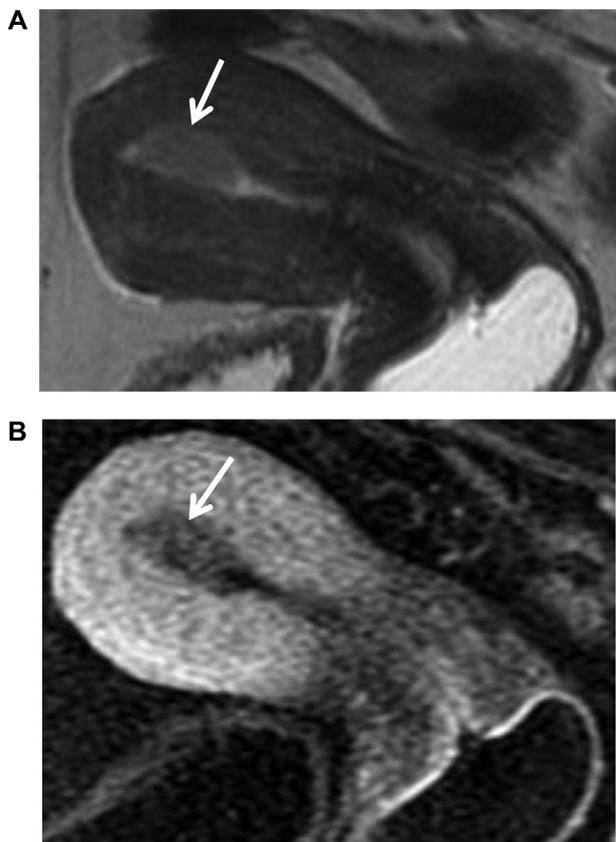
64-year-old female with endometrial cancer. (A) Sagittal T2-weighted image shows a polypoid mass (arrow) distending the endometrial cavity. It is a hypovascular tumor (arrow) presenting less enhancement than the adjacent myometrium in the sagittal post contrast T1-weighted image (B). It is a Stage IA endometrial cancer with less than 50% myometrial invasion.
